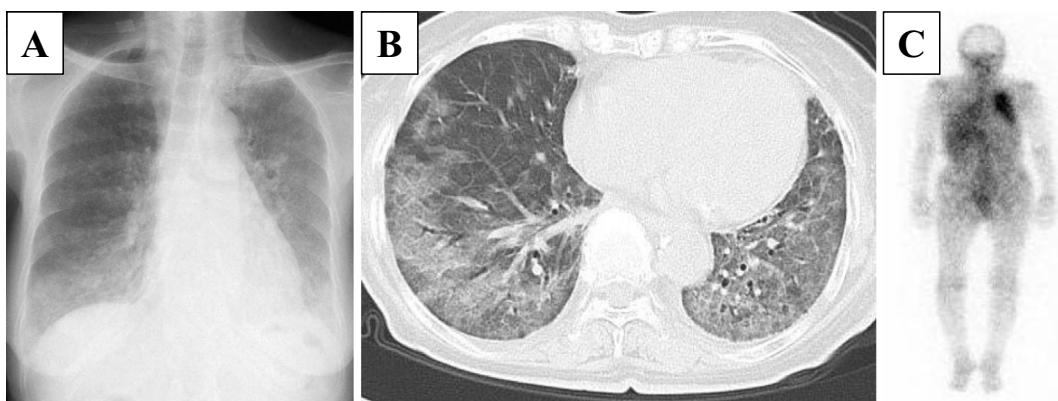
Clinical pictures before the initial treatment. (A) A chest X-ray showed diffuse ground-glass opacity (GGO) in both lung fields. (B) Chest CT on admission showed diffuse infiltrative shadows and GGO with air-bronchogram on the dorsal side of both lower lobes. (C) Gadolinium scintigraphy showed accumulation in the left upper and middle lung field, and lower right lung field.
